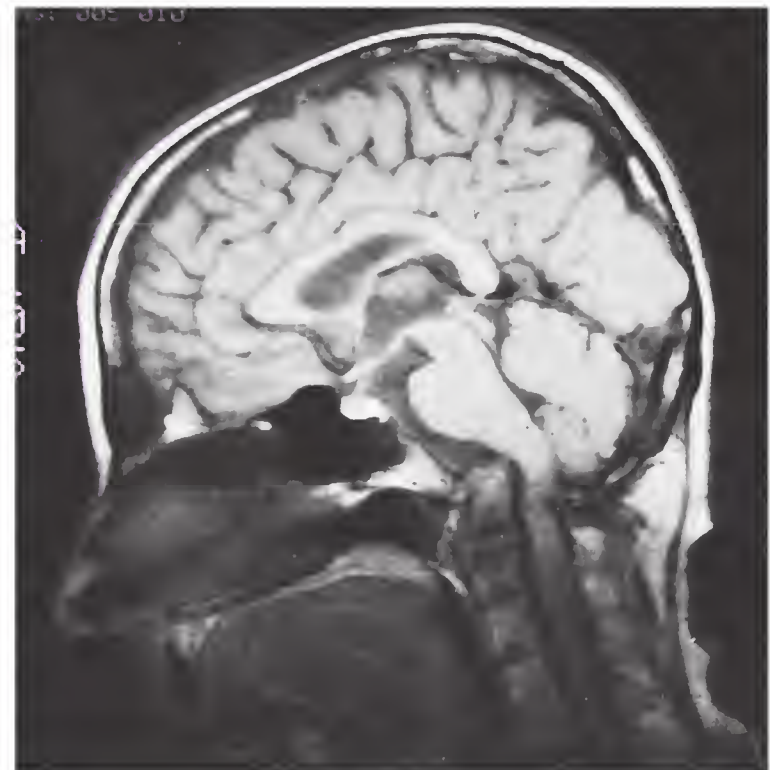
Magnetic resonance image of the cervical spine showing basilar invagination.
